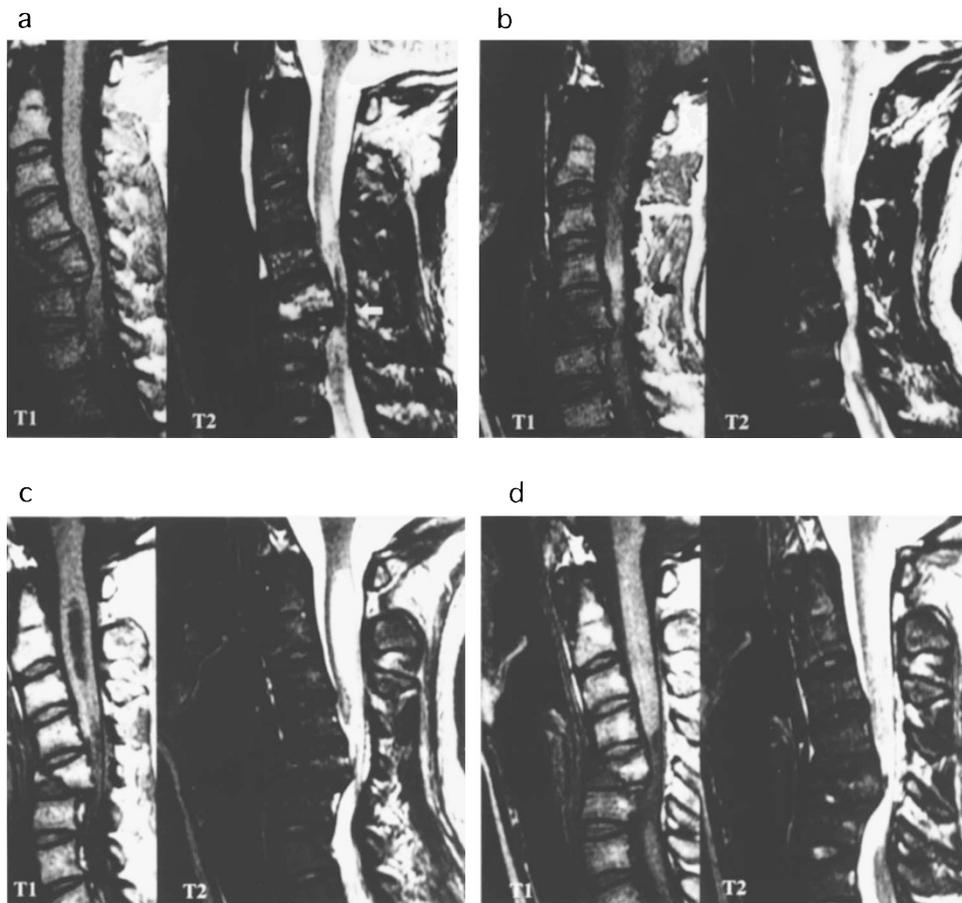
A 19-year-old woman. Paralysis was grade A at the time of injury and showed no improvement. (a) MRI at 14 h after injury. A small low signal intensity area (white arrow) within a high signal intensity area was observed on T2-weighted images, while no signal changes were observed on T1-weighted images. (b) MRI at 2 weeks after injury. The low intensity area had disappeared and a high intensity area had become more distinct on T2-weighted images. An indistinct high signal intensity area was observed on T1-weighted images. (c) MRI at 3 months after injury. The high intensity area was more extensive on T2-weighted images, and a low signal intensity area was observed on T1-weighted images. (d) MRI at 1 year after injury. The areas of signal change had decreased in size and had become more distinct
